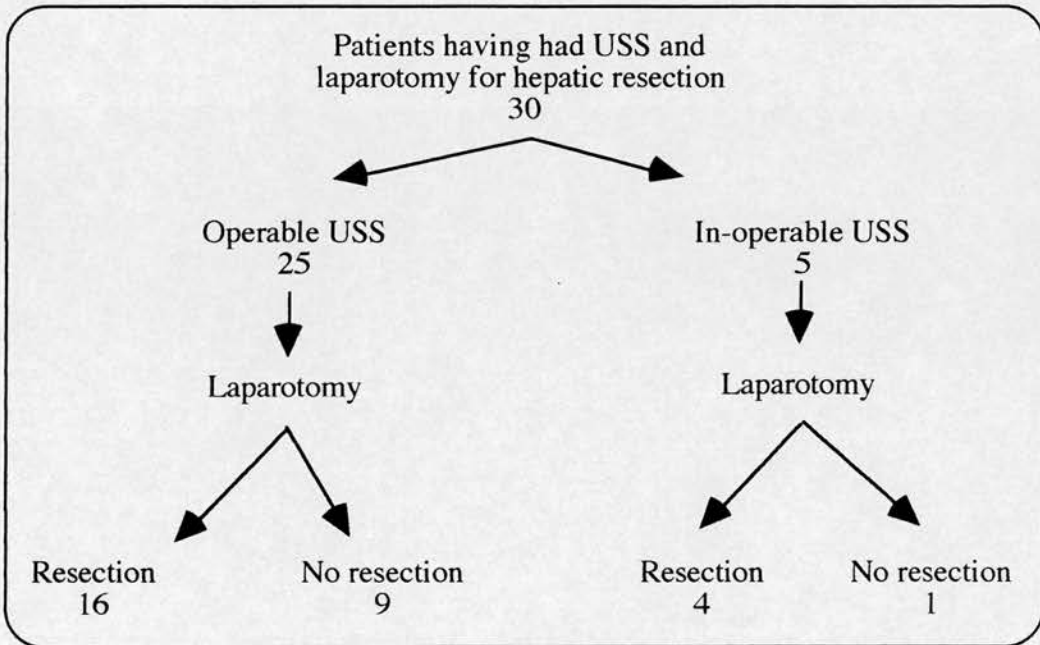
Algorithm for the investigation and treatment of patients who had preoperative ultrasonography and went on to laparotomy with the intention of performing hepatic resection
